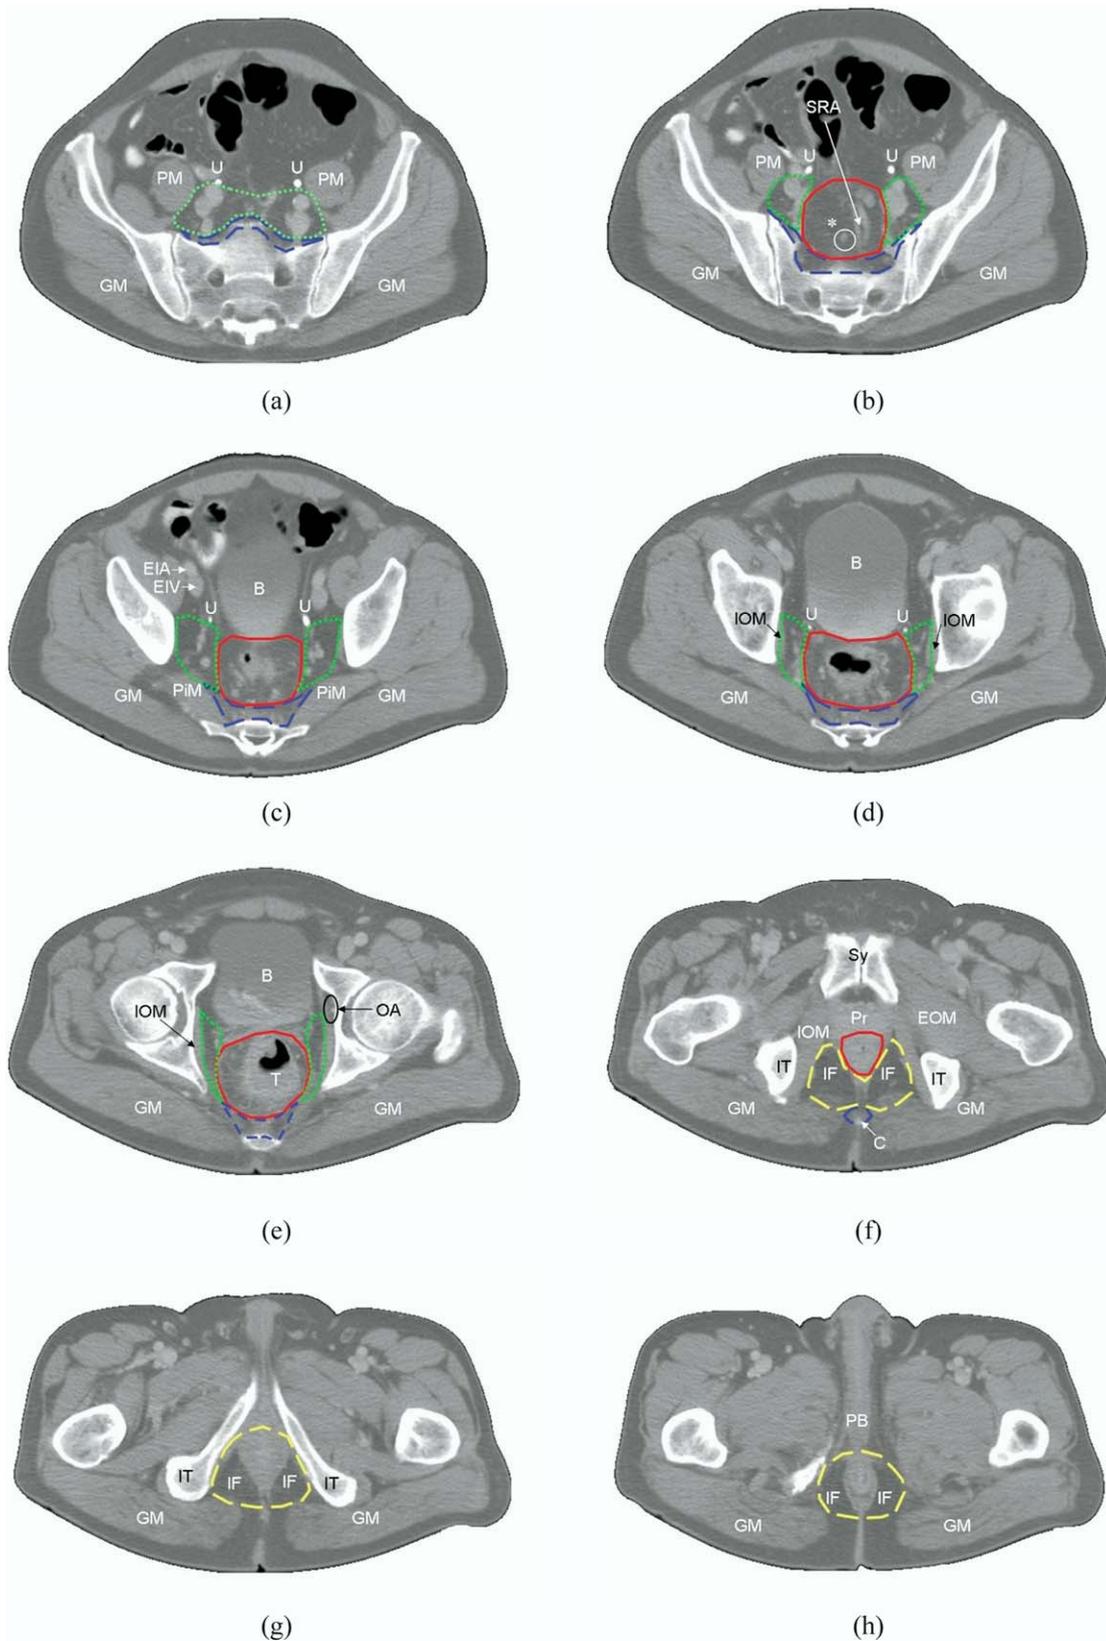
Transverse computed tomographic slices through the levels corresponding to those in Fig. 2. *Abbreviations:* B = bladder; C = coccyx; EIA = external iliac artery; EIV = external iliac vein; EOM = external obturator muscle; GM = major gluteal muscle; IF = ischioanal fossa; IOM = internal obturator muscle; IT = ischial tuberosity; LAM = levator ani muscle; OA = obturator artery; P = promontory; PB = penile bulb; PiM = piriform muscle; PM = psoas muscle; Pr = prostate; Sy = pubic symphysis; SRA = superior rectal artery; T = tumor; U = ureter. The posterior pelvic subsite (PPS) is indicated by a blue/dark dashed line. The lymph node regions are outlined by a green/bright dotted line. The mesorectal subsite (MS) is delineated by a red/full dark line and the inferior pelvic subsite (IPS) by a yellow/bright dashed line. Asterisk in (b) shows a suspect lymph node along the superior rectal artery (SRA).
